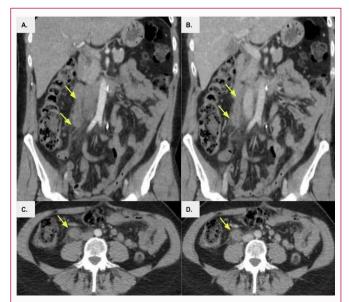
A and C) CT with coronal and axial reconstruction with contrast in arterial time. B and D) CT with coronal and axial reconstruction with contrast in portal time.
